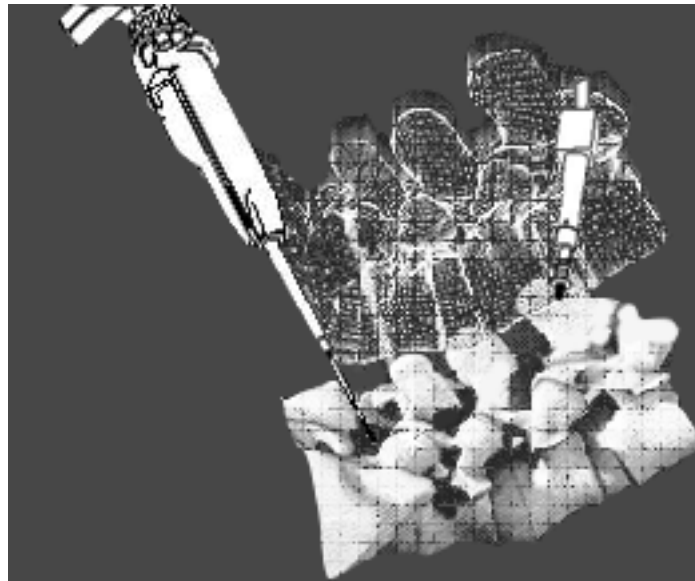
The process of registration super aligns the anatomical x-ray images to the patient's anatomy with submillimeter accuracy. Image also demonstrates a navigated spine handle (left) and an EM transmitter (right).
